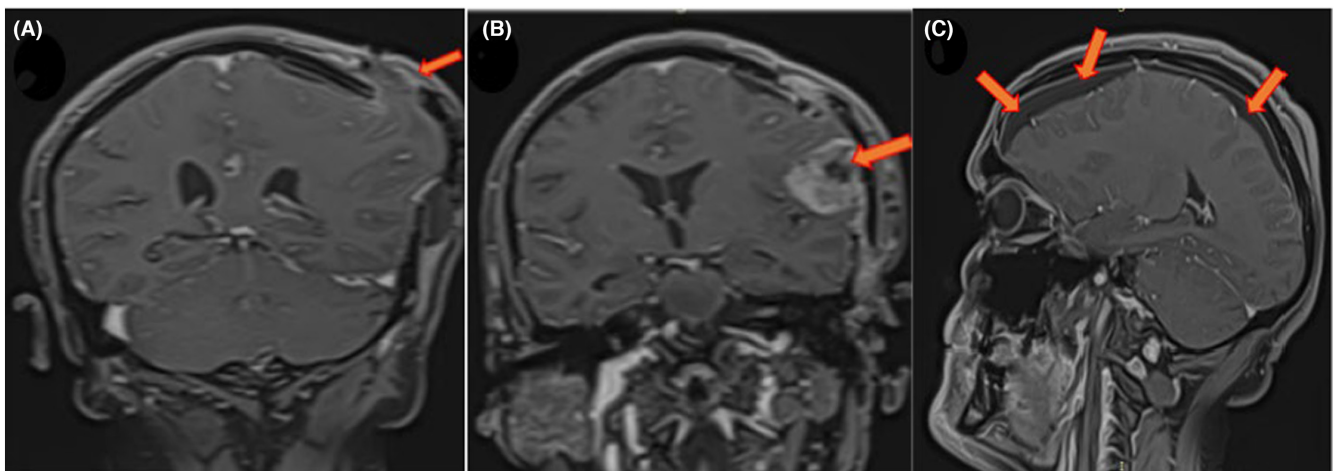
T1- Weighted coronal and sagittal views of magnetic resonance imaging (MRI) of the brain showing: (A) Displaced bone flap and herniation, (B) Residual tumor, and (C) Subdural hygroma.
